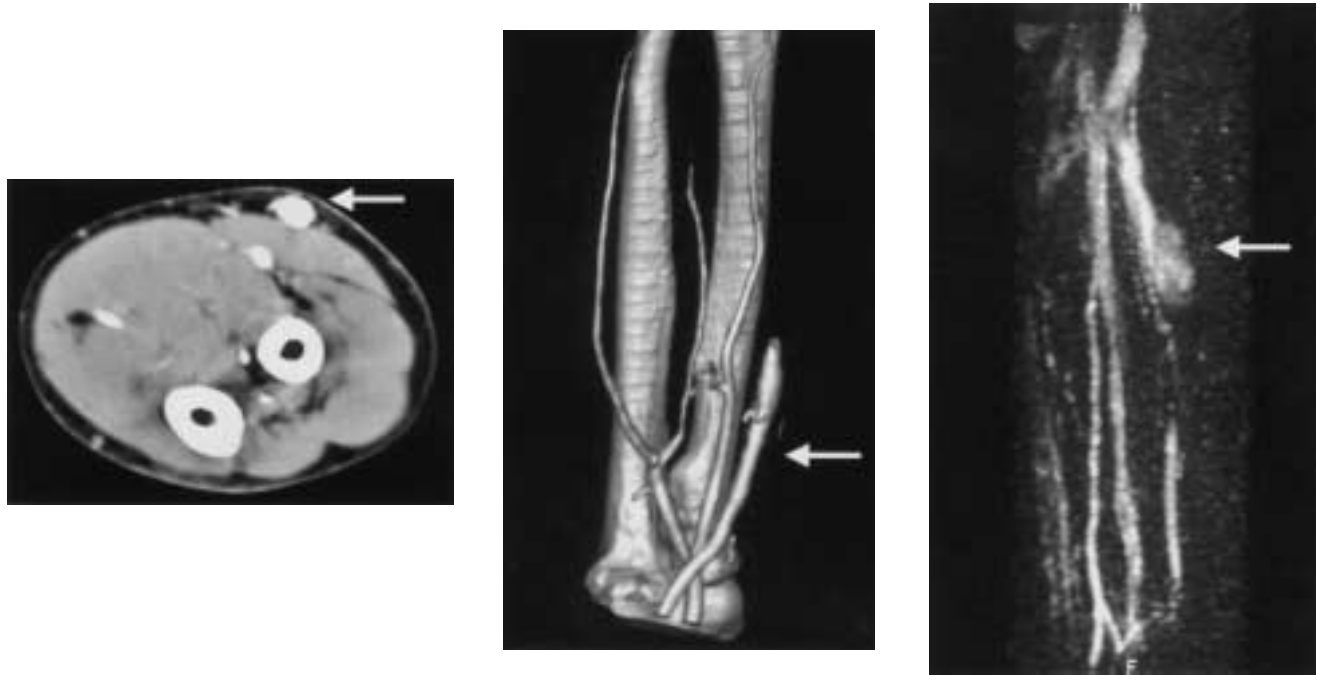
Contrast enhanced CT scan (A), Three-dimensional CT scan (B) and MRI of the right forearm showed venous dilation and early venous filling. The right radial artery and the cephalic vein (arrows) were enhanced simultaneously. A | B | C
